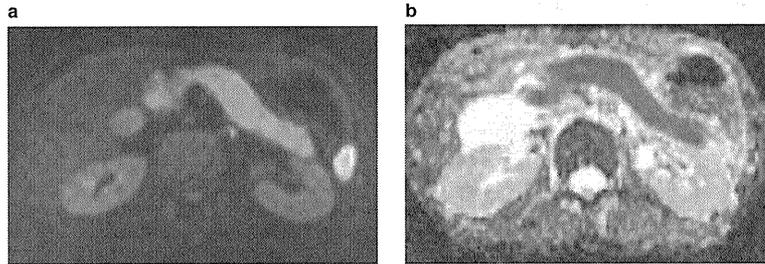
Diffuse-type autoimmune pancreatitis. (a) Diffusion-weighted magnetic resonance image showing a diffusely swollen high-intensity area (*b*=800 mm²/s). (b) ADC map in the same patient. ADC, apparent diffusion coefficient.
